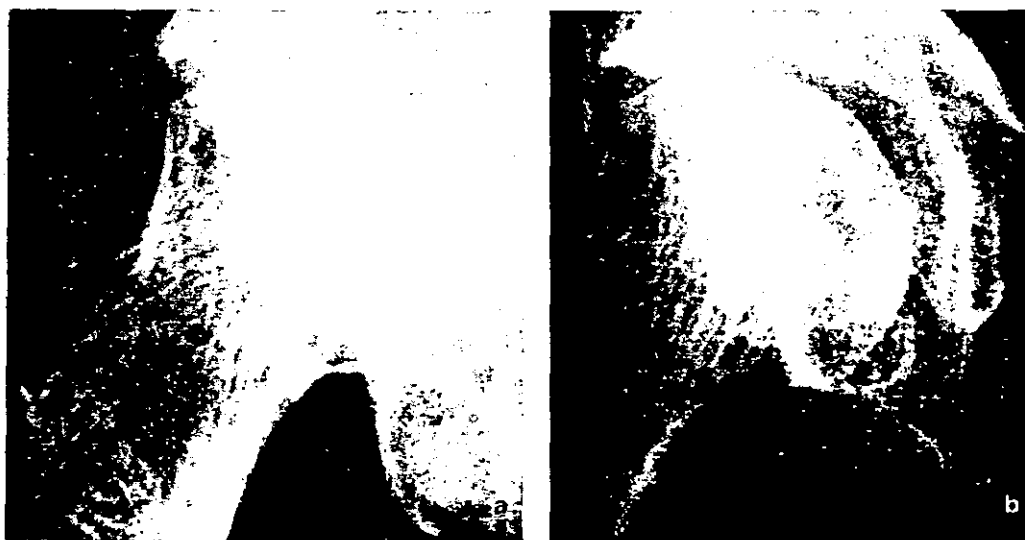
(a) Underpenetration of the left femoral head and the trabecular structure is not clearly defined. (b) Repeat radiograph with increased kilovoltage clearly defining osteonecrosis with a dense layer in the right femoral head and an intact articular cortex.
